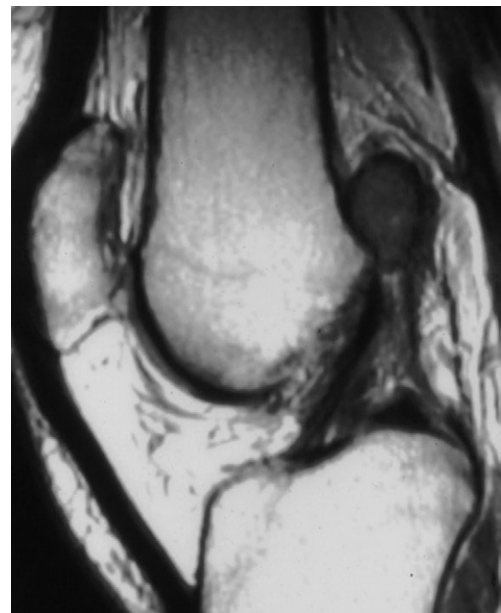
Magnetic resonance image shows well-delineated dark mass in posterior knee joint.
